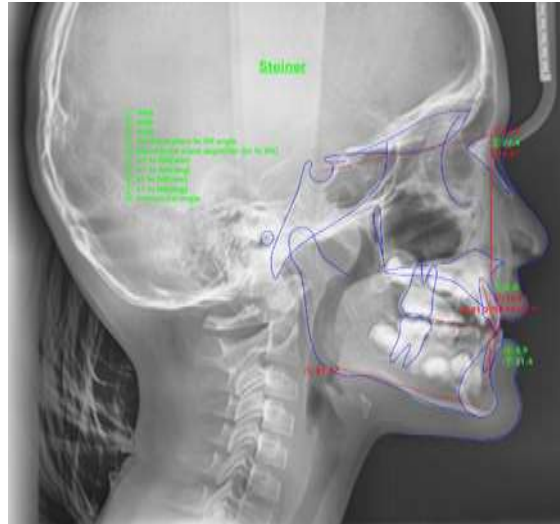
Lateral Cephalometric Radiograph Before Treatment and Steiner Analysis
